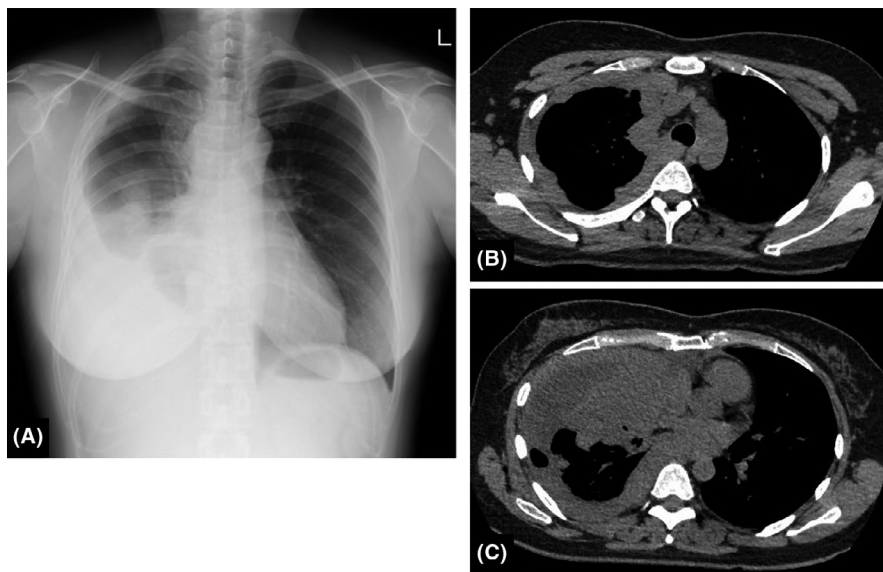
Radiological findings at admission to our hospital. Chest X-ray showed decreased radiolucency in the right upper-peripheral, middle, and lower lung fields with dullness at the right costophrenic angle (A). Chest computed tomography shows diffuse thickening of the right pleura with effusion (B, C)
